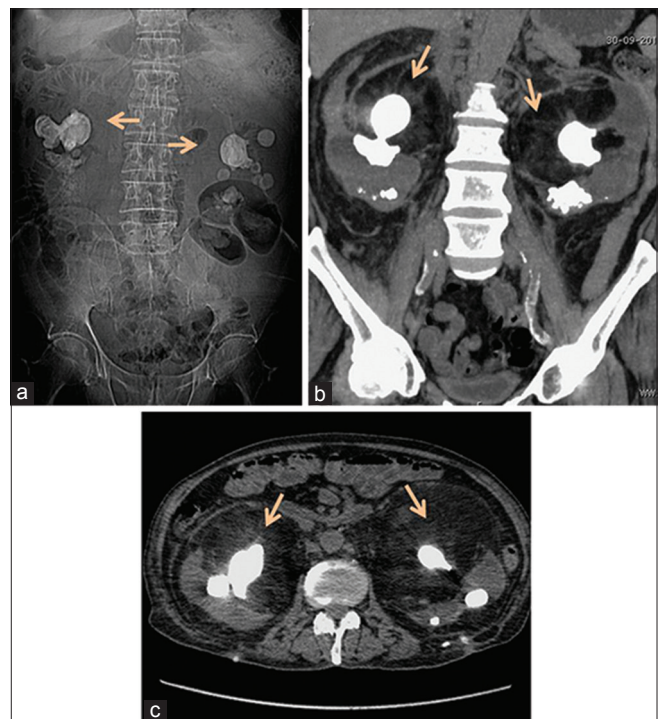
(a) Computed tomography (CT) scout image showing bilateral staghorn calculi (arrows) with surrounding halo of lucency (b and c) Coronal MIP and axial noncontrast CT images showing bilateral staghorn calculi (arrows) resulting in nephromegaly and hydronephrosis with marked fat proliferation and adjacent inflammatory stranding
